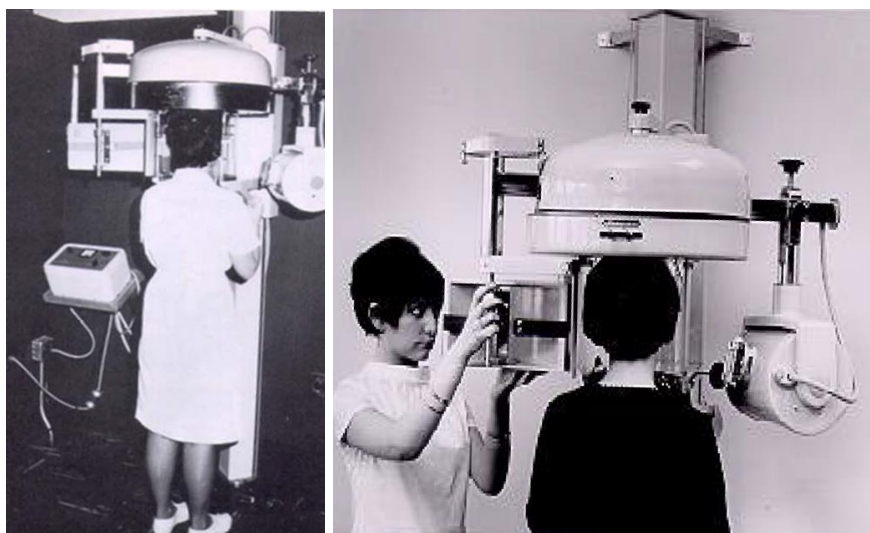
The Orthopantomograph OP1 (1961-1964, Instrumentarium, Tuusula, Finland). Courtesy of Instrumentarium Oy and J. Mudrak.
